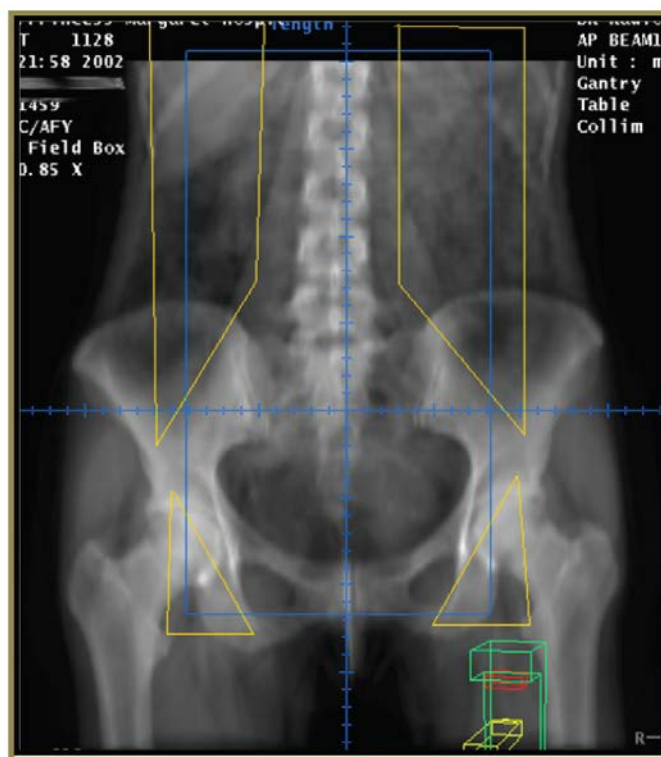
Digitally reconstructed radiograph of a continuous pelvic and para-aortic field.
